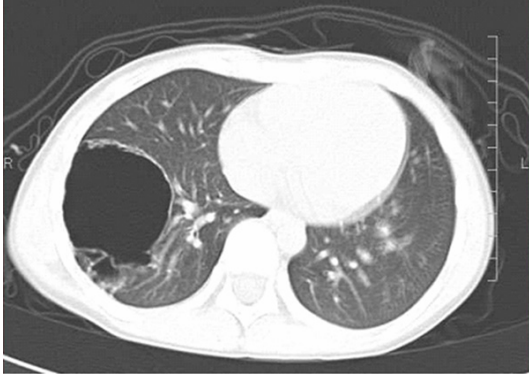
Contrast-enhanced computed tomography showing multiple cystic lesions in the right lower lung. The size of the largest one is 6 x 5 cm in diameter.
